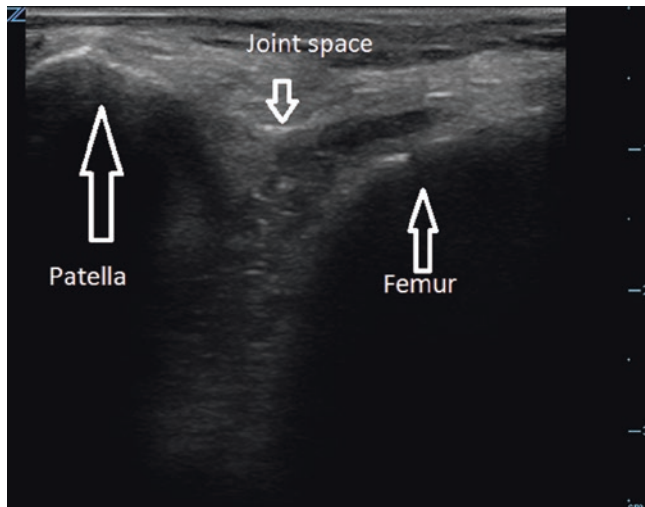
In evaluating a knee or joint effusion, place the linear probe over the area of fluctuance. Ultrasound the contralateral side of the same area for comparison. Image courtesy of Errel Khordipour
